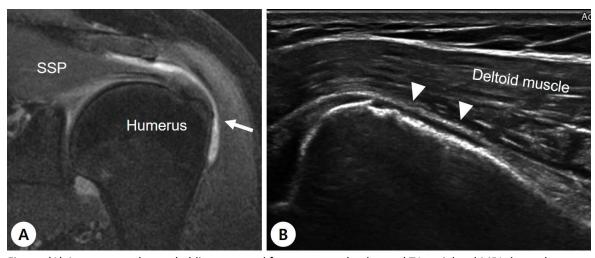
(A) A contrast enhanced oblique coronal fat-suppressed enhanced T1-weighted MRI showed contrast enhancement of subacromial-subdeltoid (SASD) bursa (white arrow). (B) A corresponding ultrasound image revealed some fluid collection in SASD bursa (arrowhead). Abbreviation: SSP, supraspinatus muscle; GT, greater tuberosity.
